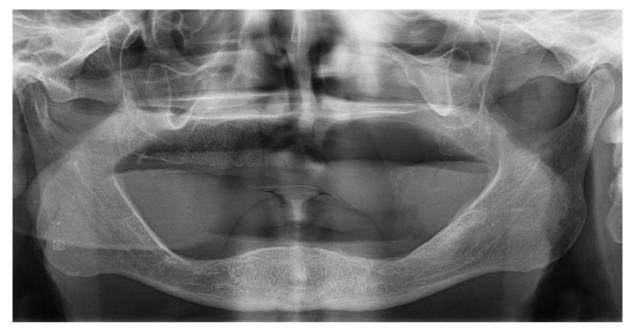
Panoramic radiography shows a large, well-circumscribed radiolucency lesion involving the left maxillary region with a well-defined border.
